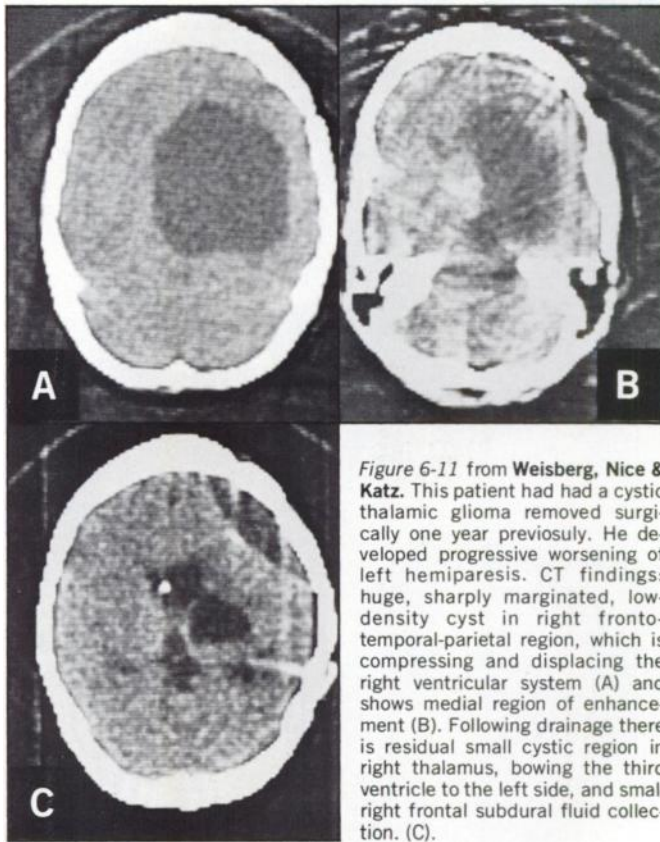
from Weisberg, Nice & Katz. This patient had had a cystic thalamic glioma removed surgically one year previously. He developed progressive worsening of left hemiparesis. CT findings: huge, sharply margined, low-density cyst in right fronto-temporal-parietal region, which is compressing and displacing the right ventricular system (A) and shows medial region of enhancement (B). Following drainage there is residual small cystic region in right thalamus, bowing the third ventricle to the left side, and small right frontal subdural fluid collection. (C).
